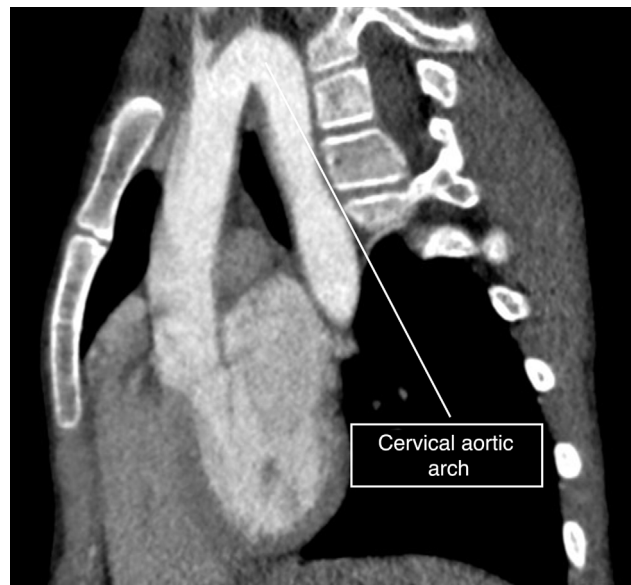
Sagittal CT image. High aortic arch superior to the clavicles.
